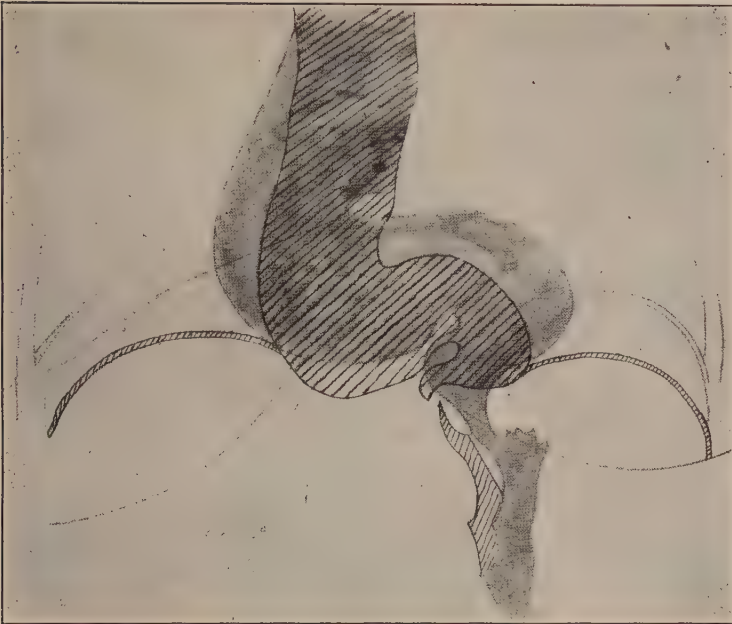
shows two superimposed esophagus tracings from X-ray plates. The plates were taken after the second intubation. In one plate the diaphragm is down, in the other it is up. When the diaphragm is down the esophagus is closed. When the diaphragm is up the esophagus is open. When the diaphragm is up the esophagus opened and the barium was discharged freely into the stomach. Before intubation nothing was seen to pass from the esophagus to the stomach.
